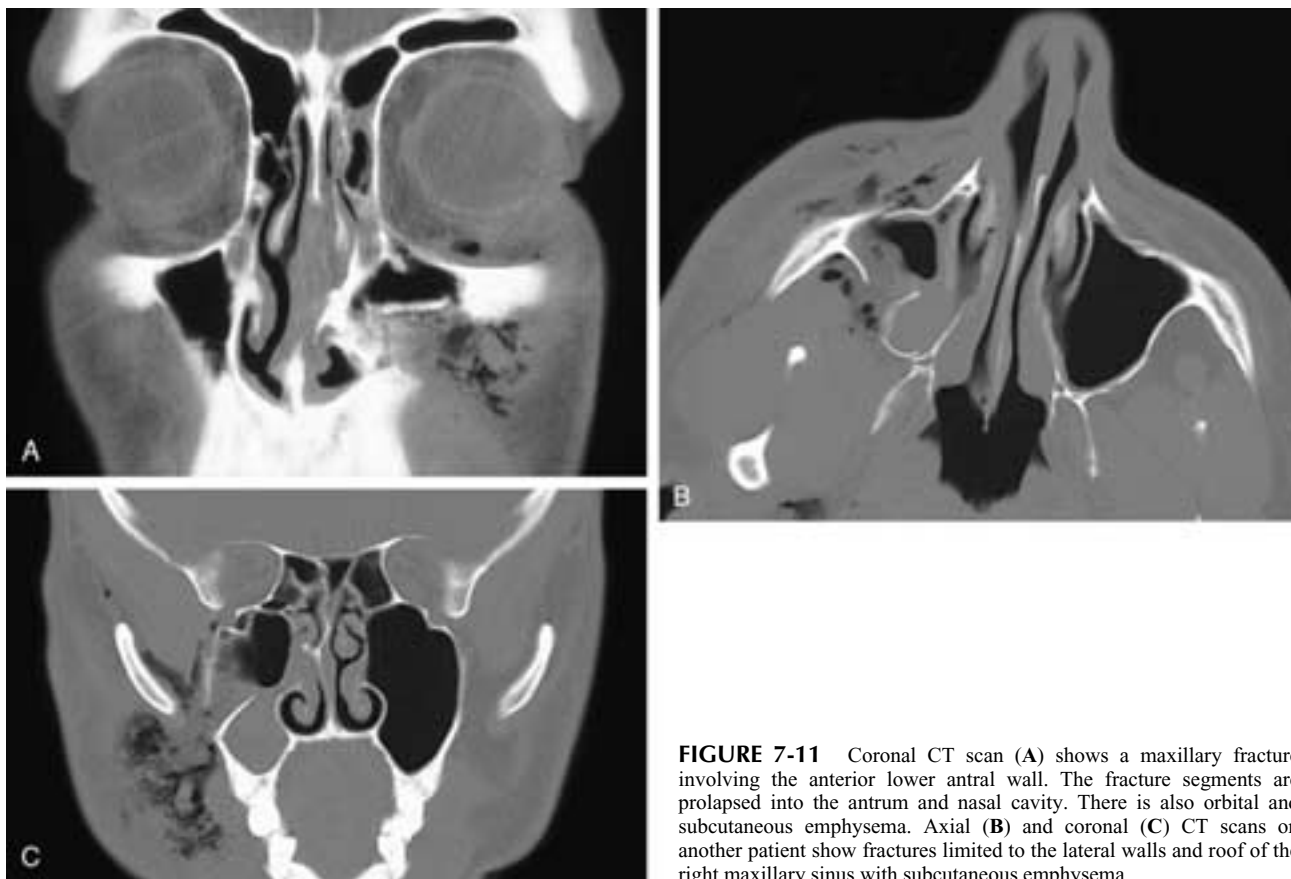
Coronal CT scan (A) shows a maxillary fracture involving the anterior lower antral wall. The fracture segments are prolapsed into the antrum and nasal cavity. There is also orbital and subcutaneous emphysema. Axial (B) and coronal (C) CT scans on another patient show fractures limited to the lateral walls and roof of the right maxillary sinus with subcutaneous emphysema.
